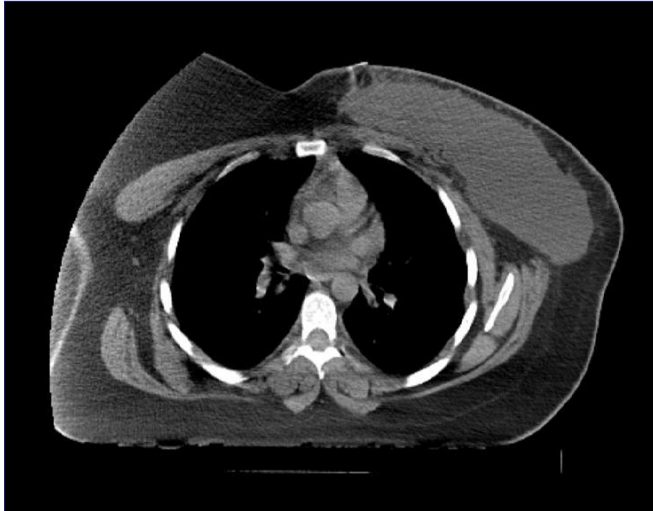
The CT scan shows the large left breast mass.
